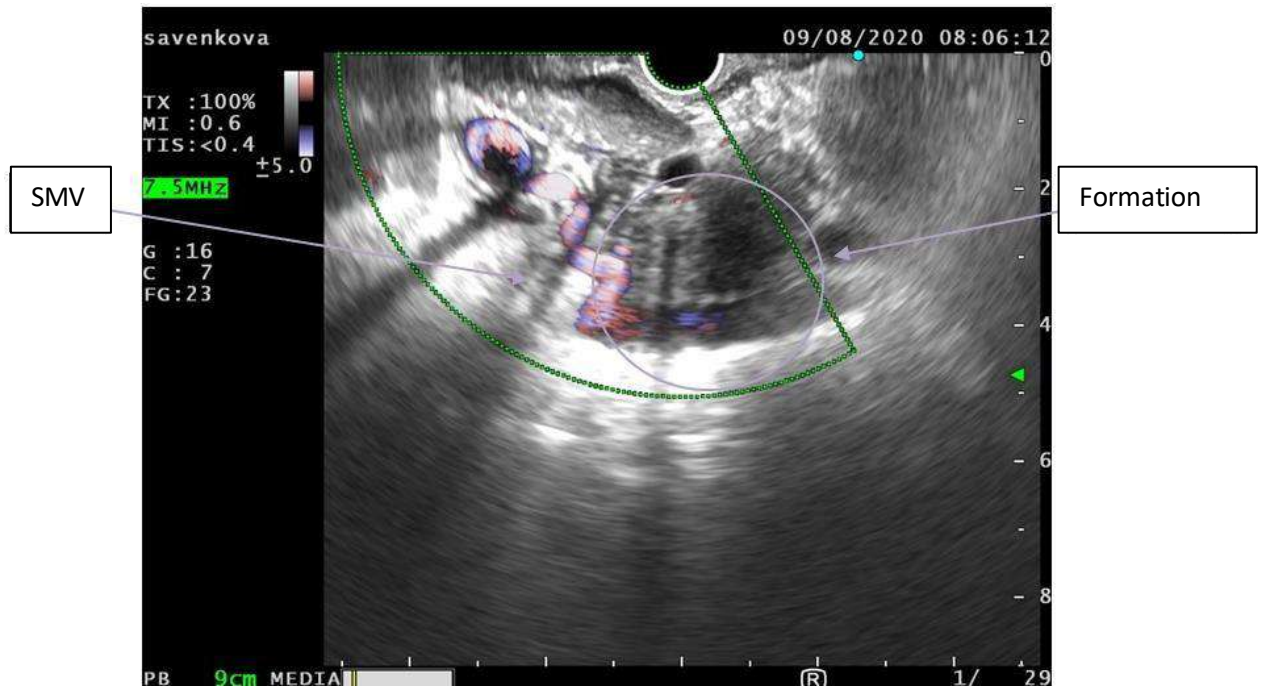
Endosonogram. An irregularly shaped hypoechoic mass with signs of invasion into the SMV is detected in the projection of the pancreas head
